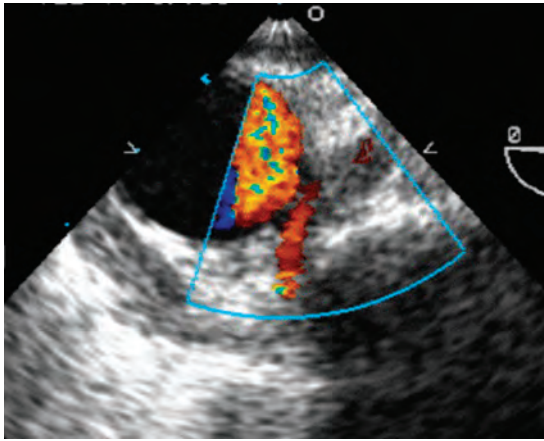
Upper esophageal transesophageal echocardiographic (TEE) short-axis view of the distal aortic arch (at zero degree of rotation). Color-flow Doppler interrogation in this view shows flow into the site of the arch transection. This flow is still contained by periaortic hematoma evident at this aortic level. The next step in the evolution of this pathology is free aortic rupture, a lethal event.
